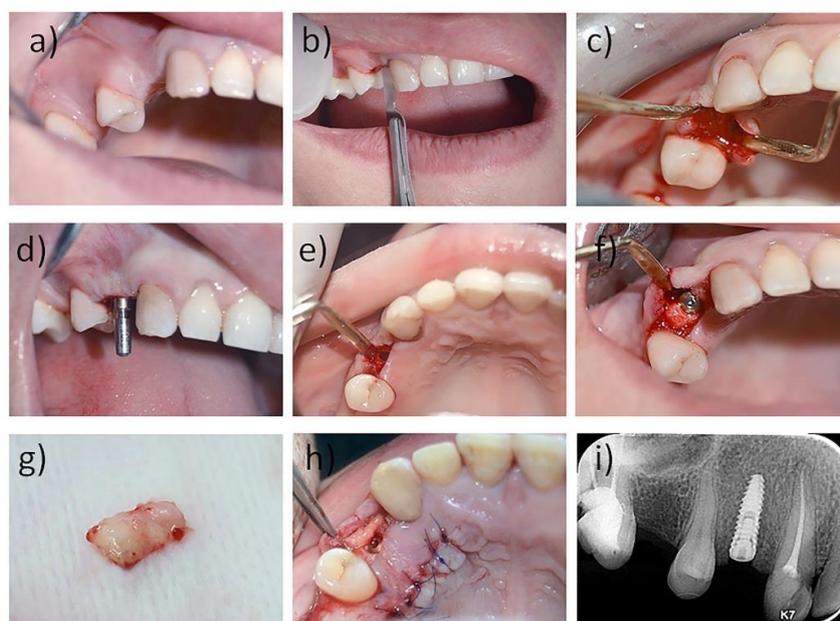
Implant placement and soft tissue augmentation with a connective tissue graft. a) Missed first premolar with thin buccal gingival phenotype, b) Midcrestal incision line, c) Full mucoperiosteal flap reflection, d) Implant positioning verification using the guiding pin, e) The completion of osteotomy site preparation, f) The dental implant placed into the osteotomy site and covered with a cover screw, g) Harvesting the connective tissue graft, h) Soft tissue augmentation, i) Periapical radiograph taken immediately after implant placement.
